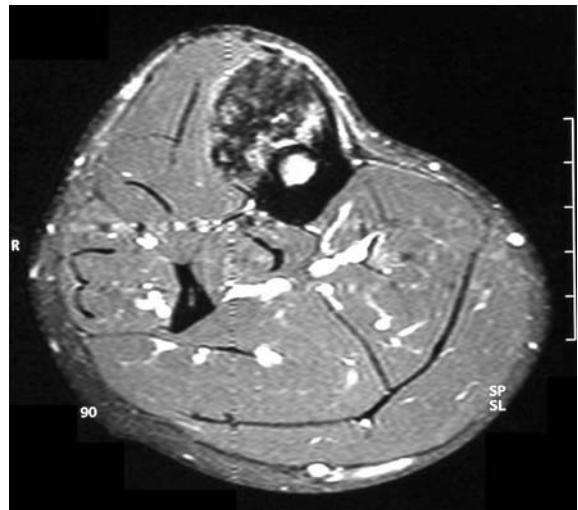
MRI of the mid-anterior tibial stress fracture with irregular bony formations (axial view).
